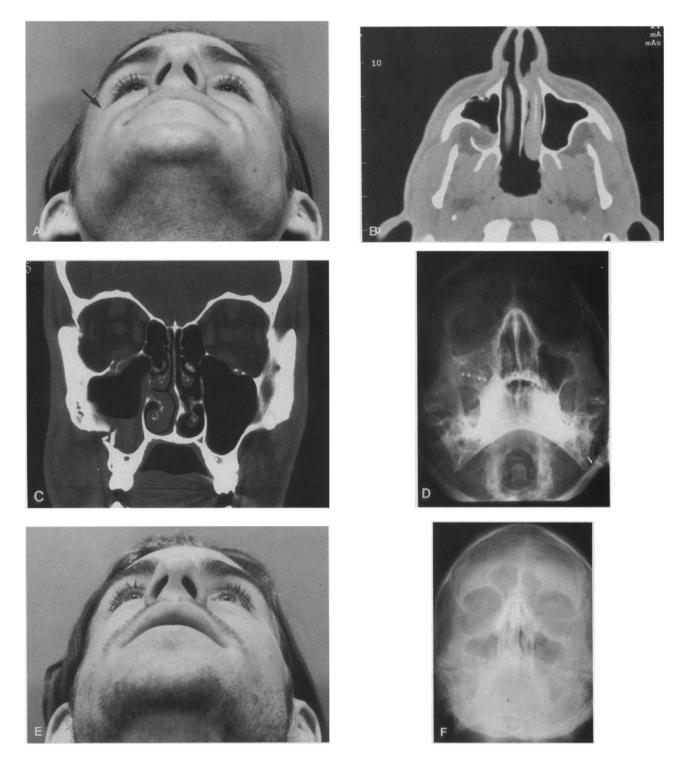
Patient treated for right ZMC fracture by reduction and fixation with a single bone plate at the zygomaticomaxillary buttress. Preoperative view showing loss of malar projection (A); axial (B) and coronal (C) CT scans showing medial rotation of ZMC. D, Immediate postoperative radiograph showing reduction. E, Appearance of patient at 5 weeks showing symmetrical result. F, Radiograph at 5 weeks showing no postreduction displacement.
